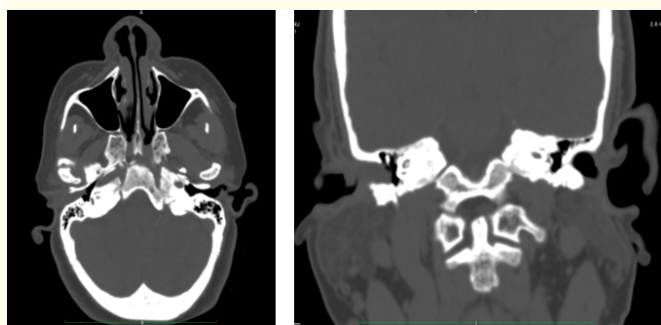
High resolution CT scan showing the lesion obliterating the right external auditory canal with no bony erosions, having preserved the surrounding and underlying structures with apparent intact tympanic membrane.
